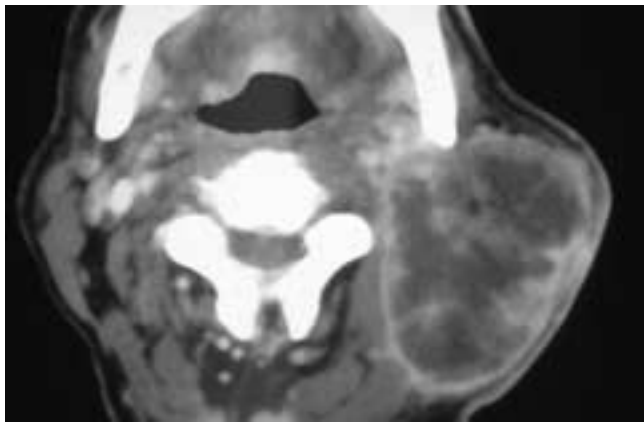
Axial contrast-enhanced CT scan shows a large necrotic mass in the left parotid gland. Some of the tumor borders are poorly defined. Clinically, this was a rapidly enlarging mass. This patient had an SCC of the parotid gland.
